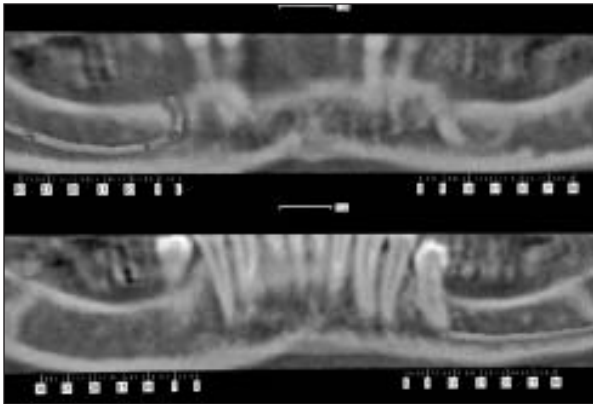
Preoperative CT showing coronal sections of the mandible.
